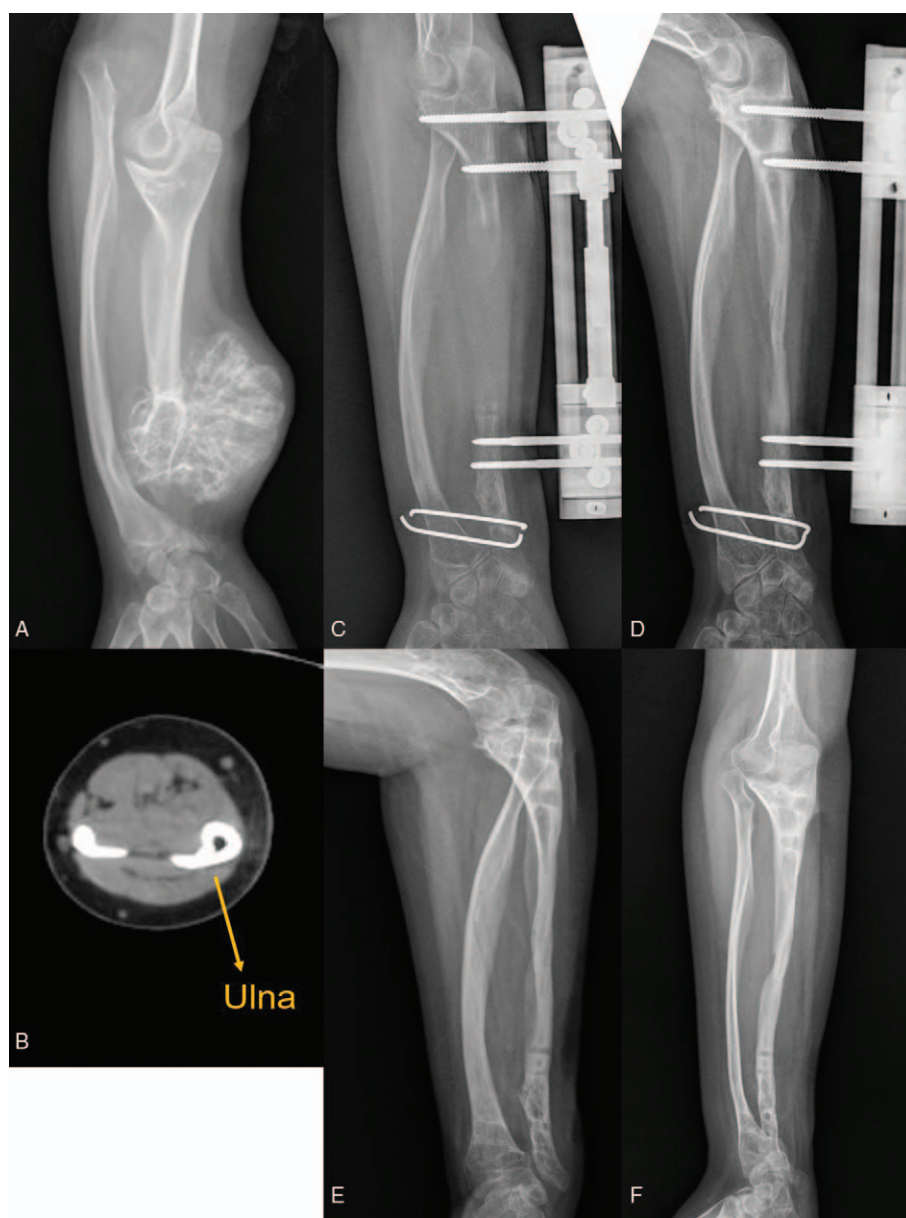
A 15-year-old boy was presented with Masada type IIb forearm deformity: (a) The growth of distal ulna epiphysis was disturbed by a huge exostosis. (b) Although the ulnar looks thick on the radiograph, CT scan showed a small diameter of the ulna. (c) The distal radioulnar joint was temporarily fixed by 2 k-wires in order to maintain the traction of the radius, the gained length of this boy was 8.6 cm and the lengthening percentage was 46.8%, however, the distraction callus could not be observed 365 days after the osteotomy. (d) This boy was treated with autologous iliac marrow cancellous bone grafting with BMP, the external fixator was kept to maintain the stability till the bone union. (e, f) One year follow-up after external fixator removal, although radial head was not reduced, the appearance and the function were much improved. BMP=bone morphogenetic protein.
